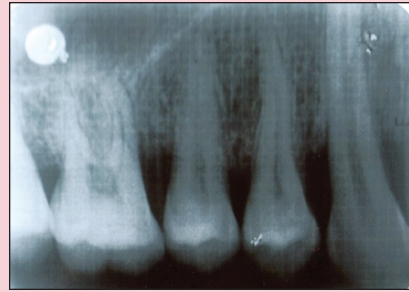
Postoperative radiograph of the test site at 3 months.
